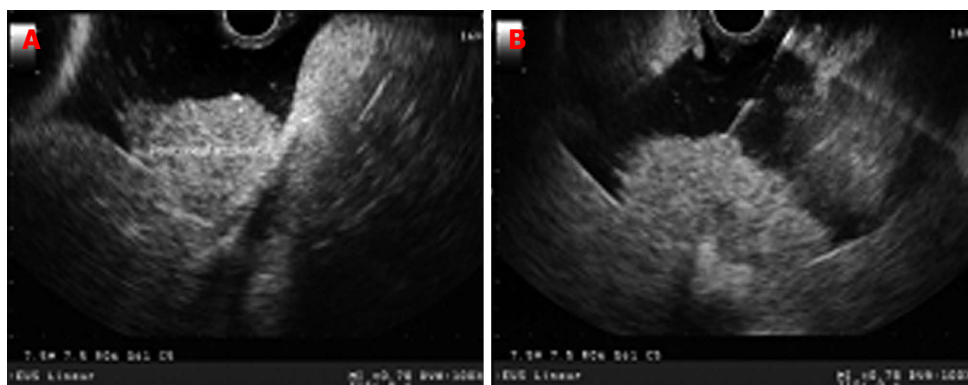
Peritoneal deposits in a patient with malignant ascites. Peritoneal implants appear as hypoechoic in comparison to the surrounding tissue but hyperechoic in comparison to the anechoic ascitic fluid (A); endoscopic ultrasound-guided fine needle aspiration of a large peritoneal deposit (B).
